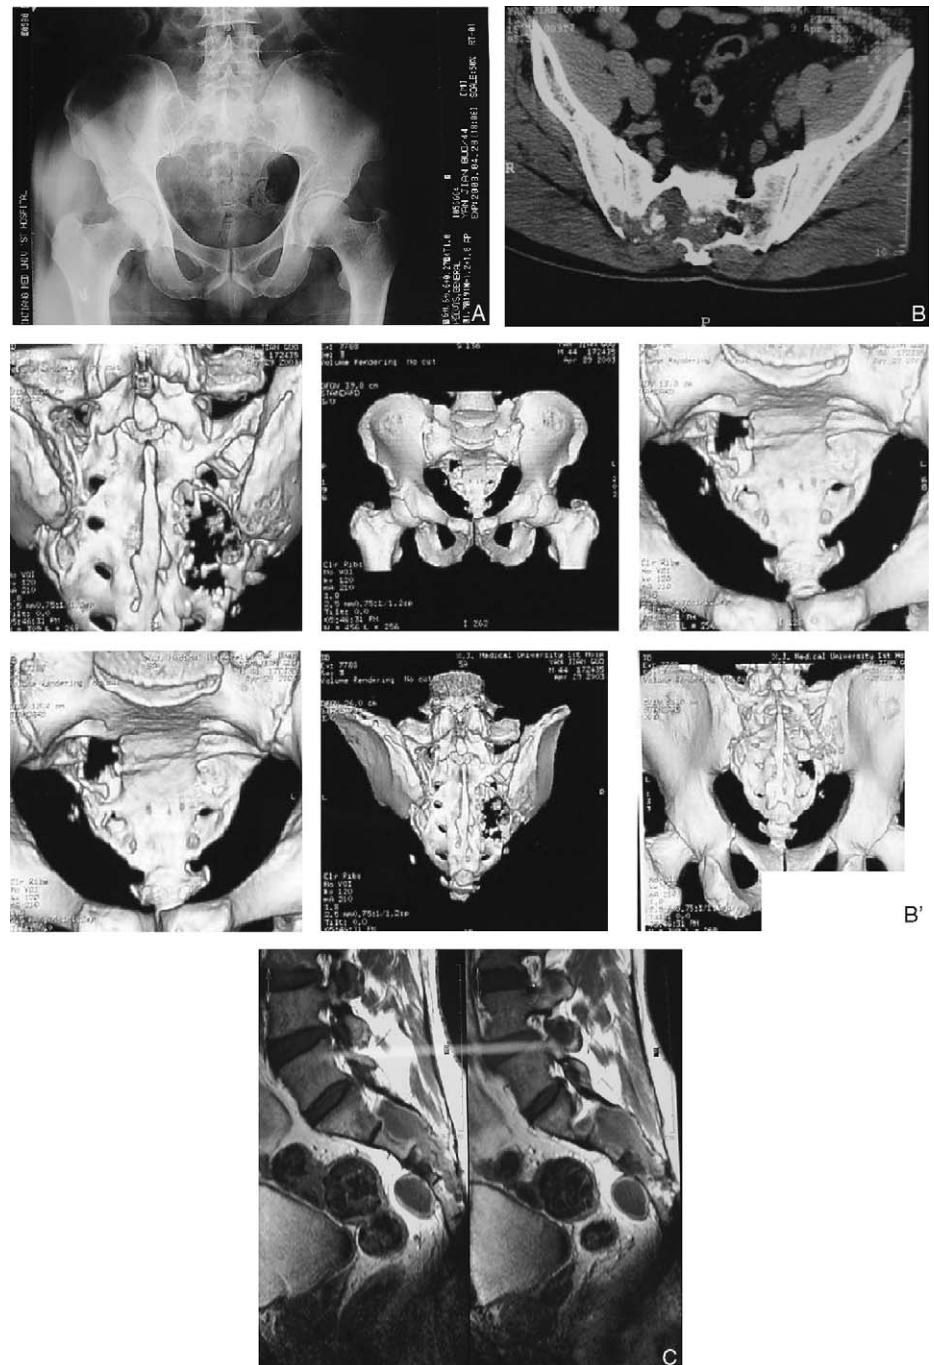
A, The radiograph showing the destructive region in the sacrum. B, The sacral bone destruction combined sequestrum on CT scan. B', The sacral bone destruction on CT scan of 3-dimensional reconstruction. C, MRI showing the occupying lesion in the spinal canal, and in anterior sacrum.
